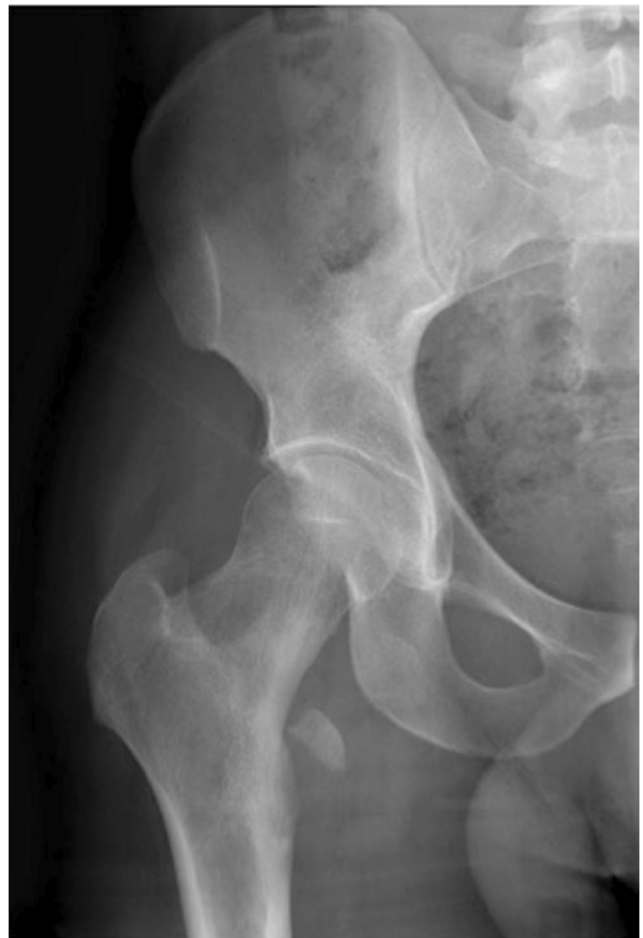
AP (anteroposterior radiograph) of the right hip
